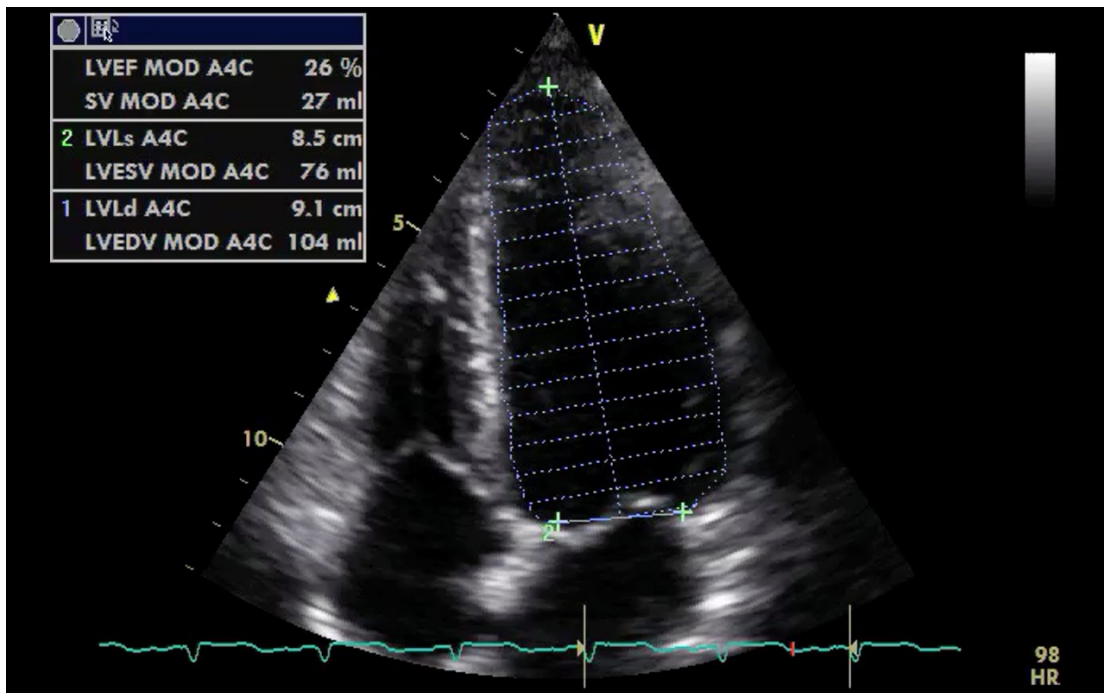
Echo demonstrating a left ventricular ejection fraction (LVEF) of 26%. LVESV: Left ventricular end-systolic volume, LVEDV: Left ventricular end-diastolic volume, SV: systolic volume, MOD A4C: method of discs apical 4-chamber.
